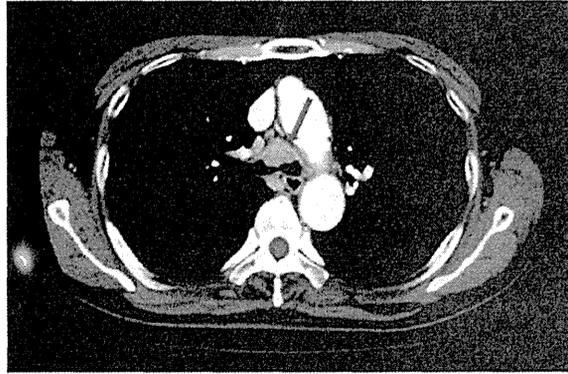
Chest computed tomography scan. The tumor measured 25x20x15 mm and was located directly above the carina and protruded from the anterior wall of the trachea (arrow).
